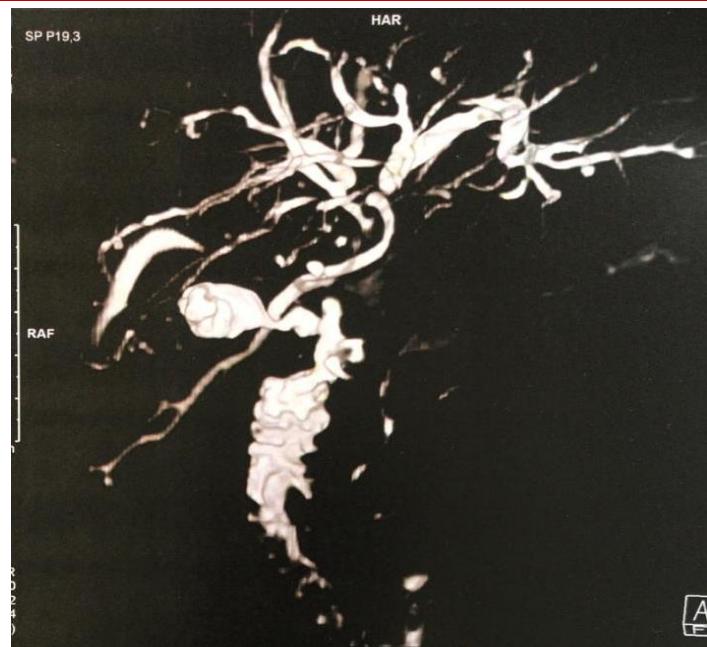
Cholangio-MRI shows a stenosis of upper biliary confluence with a virtual CBD.
